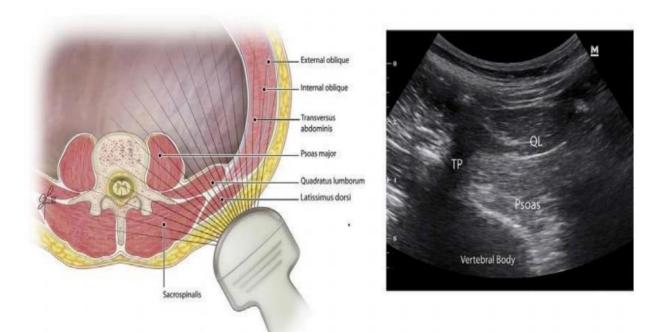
QL BLOCK (ULTRASOUND IMAGE)
